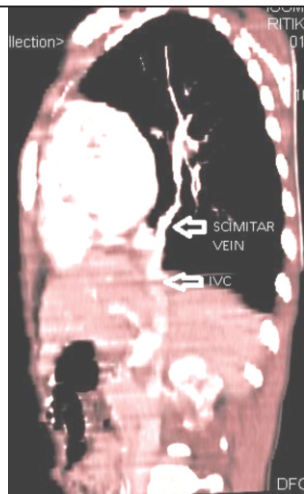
CT Angiography (lateral view) showing curvilinear opacity extending from above downwards into the diaphragm
